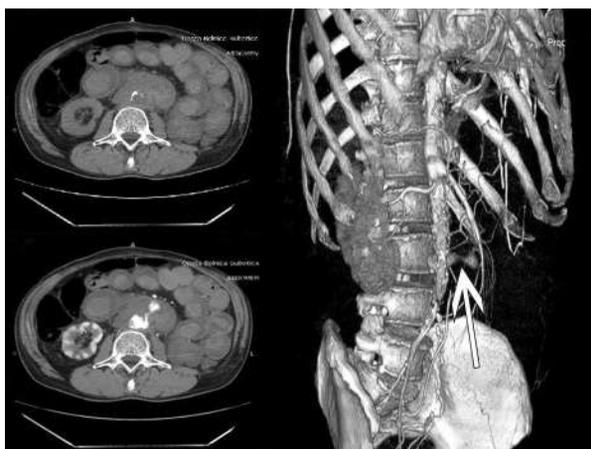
Axial view of non-enhanced phase of CTA showing dilated small bowel loops filled with hyperdense material - fresh blood; Distinct atherosclerotic abdominal aorta wall lesions; CTA showing active extravasation of the aortic contrast between the third and the fourth segment of the duodenum; 3D reconstructed image of CTA showing non-dilated abdominal aorta and confirmed contrast extravasation (red arrow)
